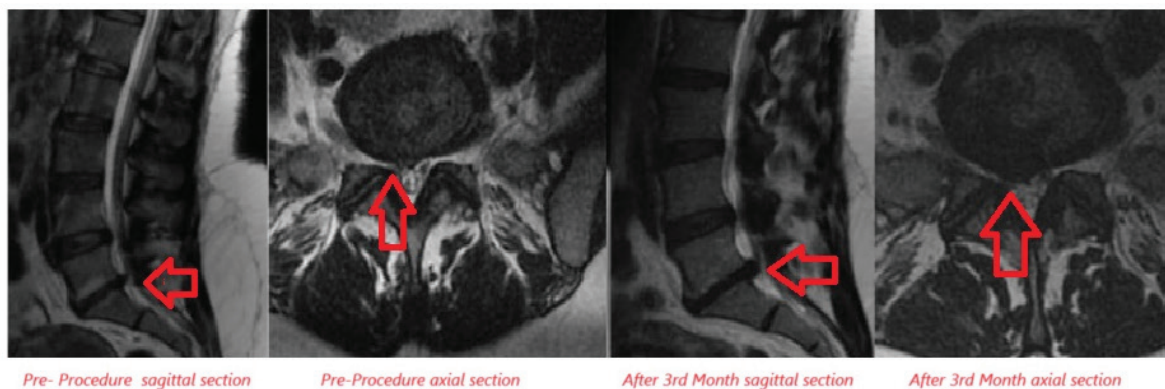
Examination of disc size increase after ozone therapy in lumbar MRI sagittal and axial sections.
